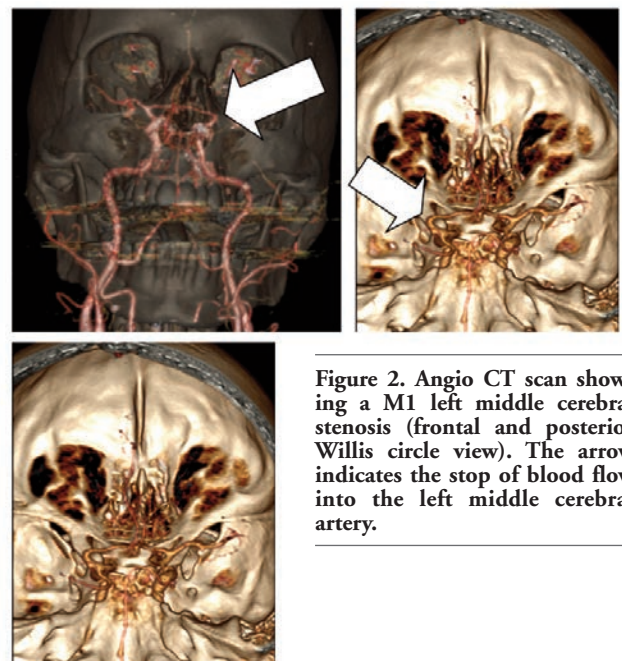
Angio CT scan showing a M1 left middle cerebral stenosis (frontal and posterior Willis circle view). The arrow indicates the stop of blood flow into the left middle cerebral artery.
